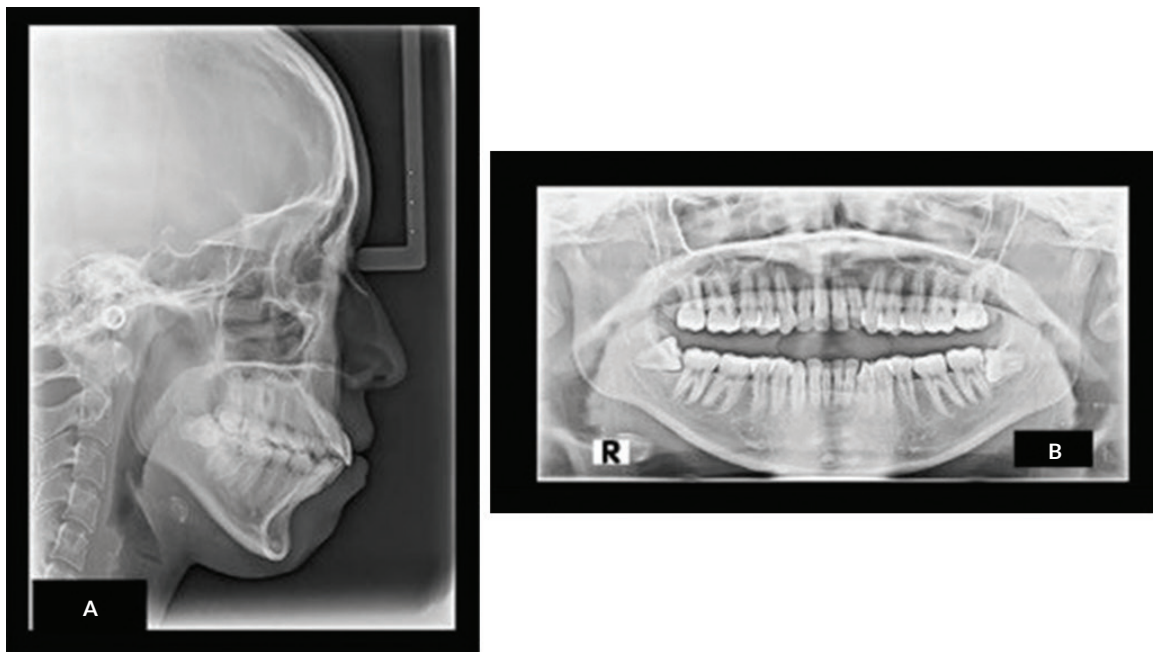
Initial (A) lateral cephalometric and (B) panoramic radiographs.
